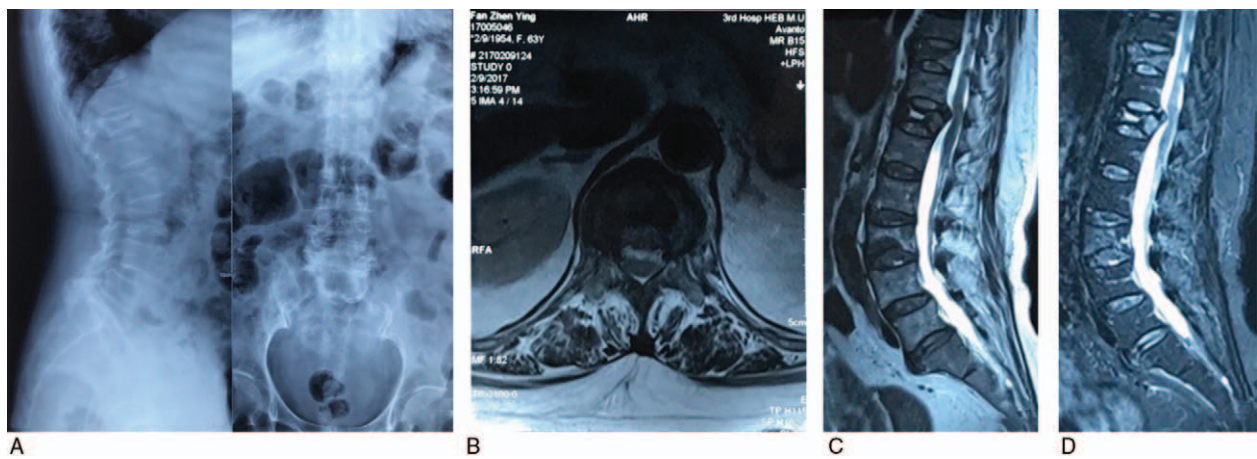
(A) Preoperative lateral x-ray. (B–D) Preoperative MRI. MRI = magnetic resonance imaging.
